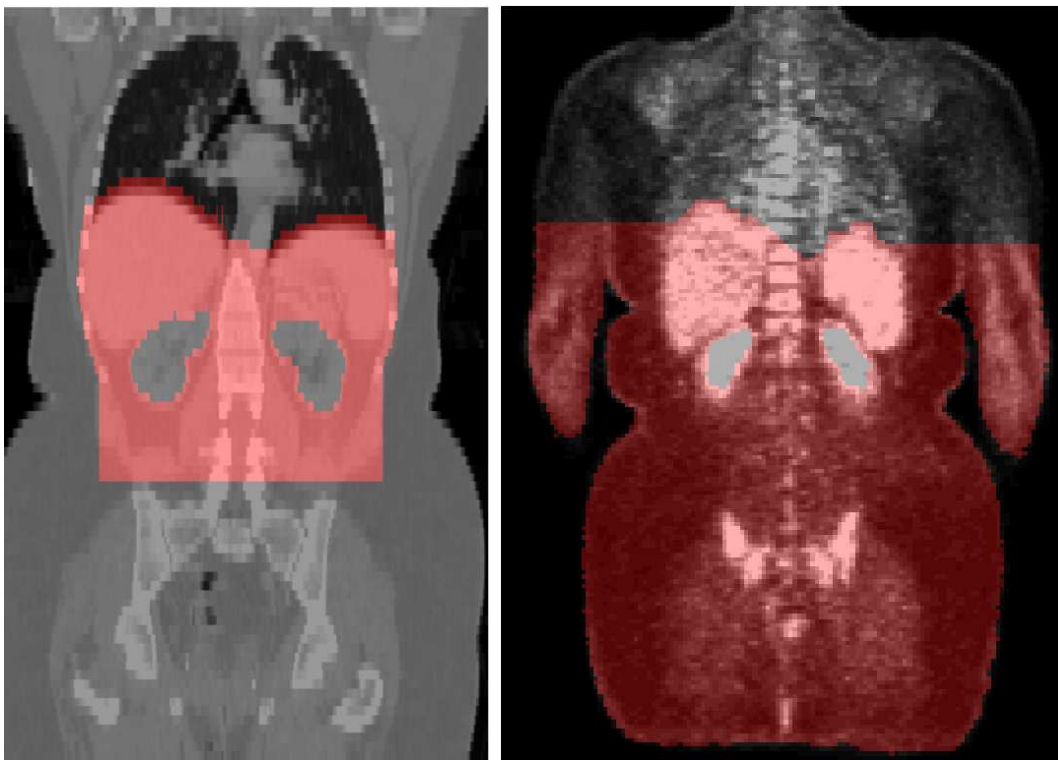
Examples of liver ROIs (in red) superimposed on grey-level images. Left: CT image; Right: PET image.
